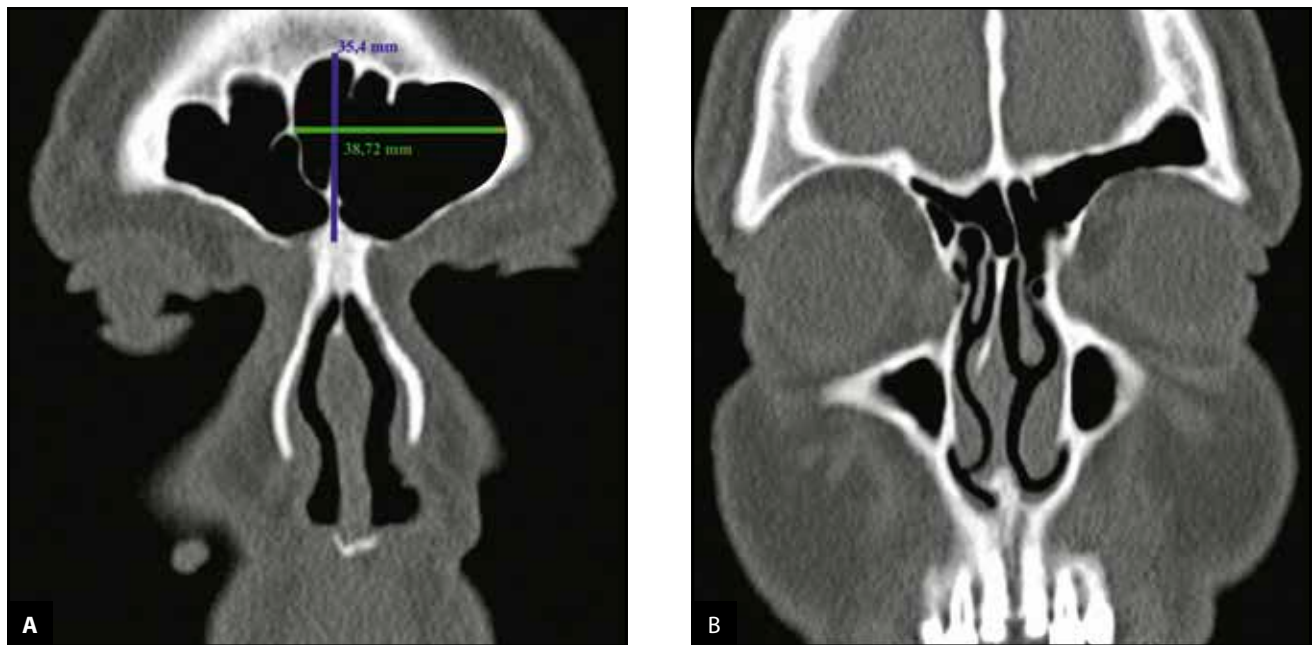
Cranio-facial native CT scan (A. and B. coronal view) A. extensive dilatated left frontal sinus – height 35.4mm (blue line), width 38.7mm (green line), with no signs of mucosal or bony injury and B. Coronal view evidencing “deer horn” aspect of the left frontal sinus.
